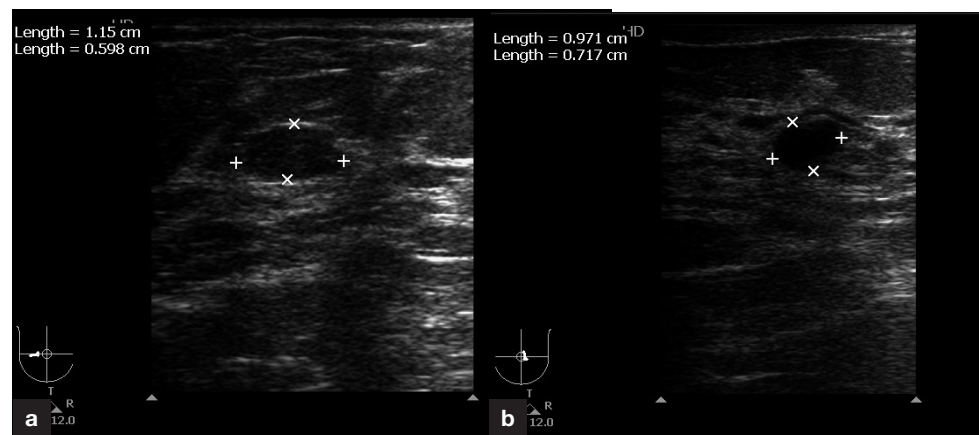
a. Ultrasound appearance of a well-circumscribed oval-shaped lesion with the width greater than the height containing internal echoes, in keeping with a fibroadenoma. b. Simple cyst.
